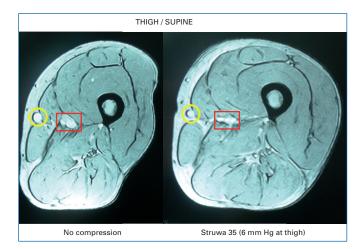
Cross section at mid-thigh level in a supine patient with a large great saphenous vein (yellow circle) obtained by magnetic resonance imaging.
